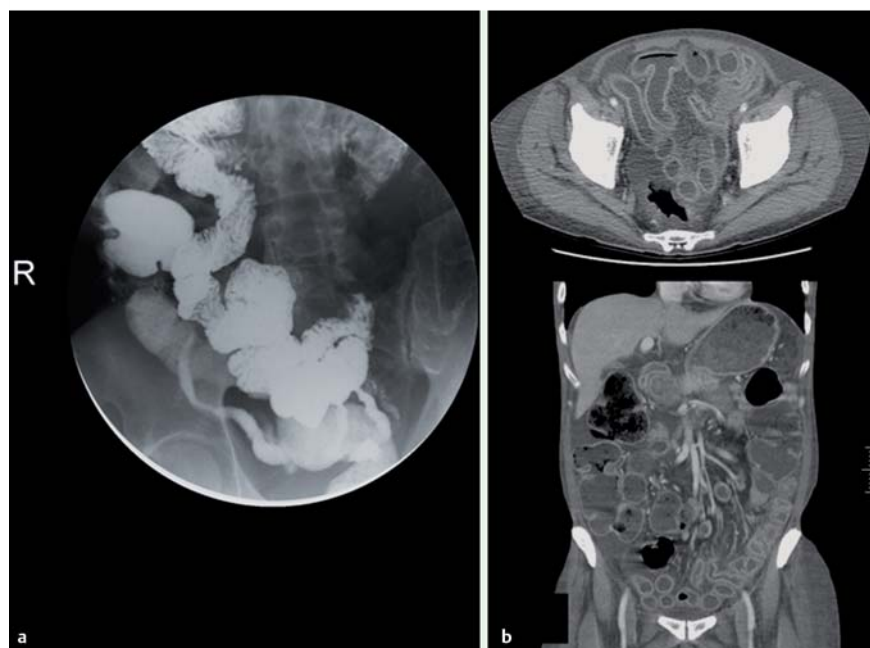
Small-intestine series and abdominal computed tomography demonstrating diffuse wall thickening of the terminal ileum.
